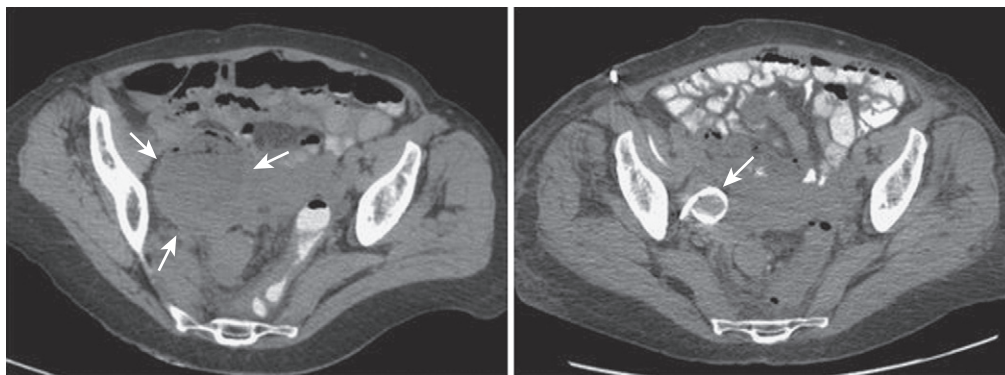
Percutaneous drainage of a pelvic abscess. An axial computed tomographic scan shows a pelvic abscess (*left panel, arrows*) that developed following a damage-control procedure in an elderly patient with complex diverticulitis. A pigtail catheter was directed into the collection (*right panel, arrow*), enabling virtually complete drainage of the collection.
